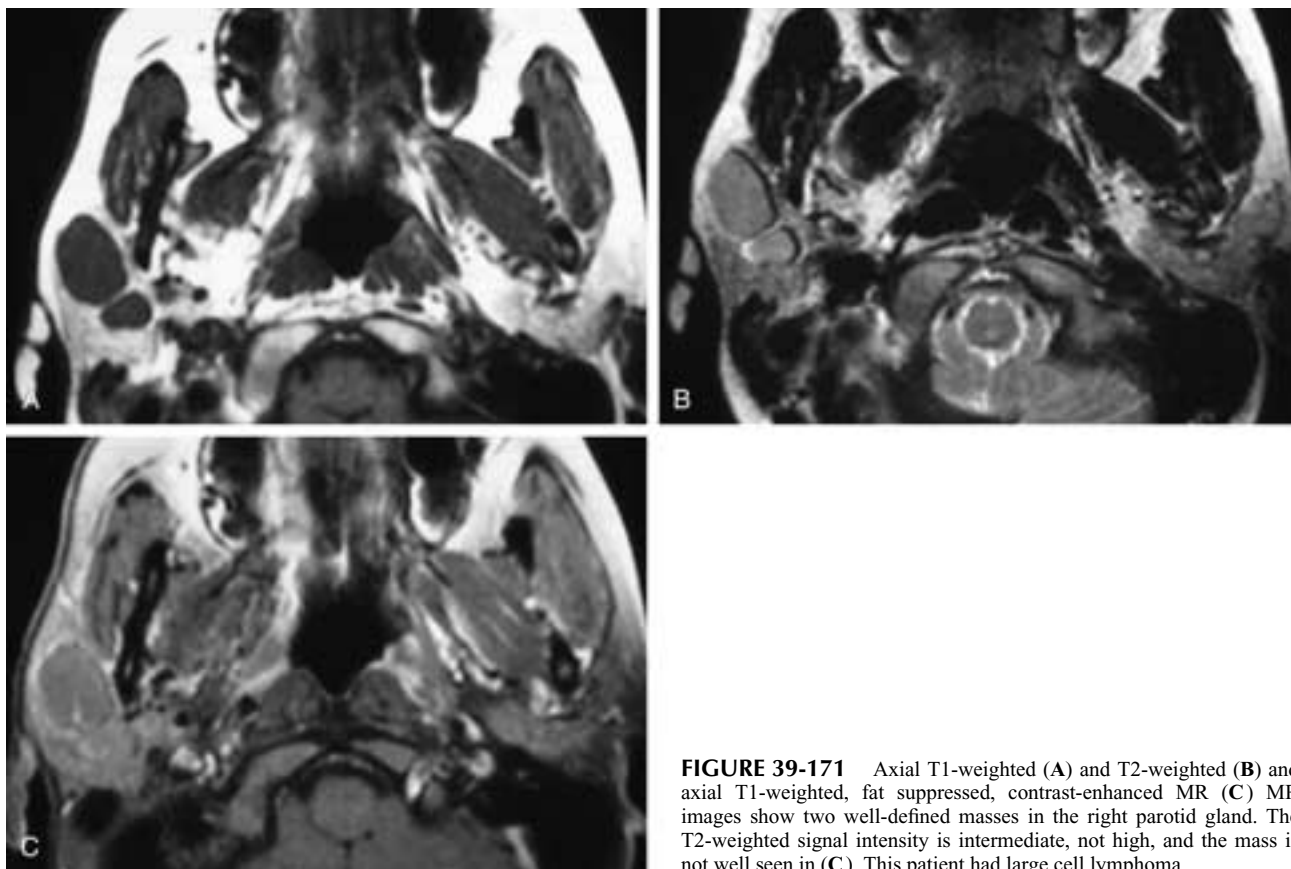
Axial T1-weighted (A) and T2-weighted (B) and axial T1-weighted, fat suppressed, contrast-enhanced MR (C) MR images show two well-defined masses in the right parotid gland. The T2-weighted signal intensity is intermediate, not high, and the mass is not well seen in (C). This patient had large cell lymphoma.
